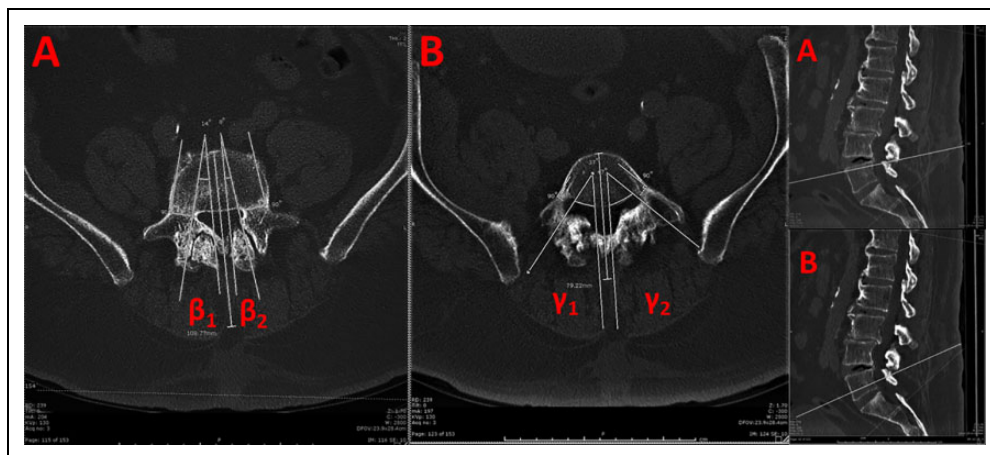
Axial and sagittal computed tomography (CT) scan images demonstrating measurement of the change in transverse pedicle angle (Δ TPA) based on the axial slice position in the cranial-caudal direction. Measurements at the (A) cephalad and (B) caudal axial sections of L5 pedicle. Cephalad TPA was calculated as $(\beta_1 + \beta_2)/2$. Caudal TPA was calculated as $(\gamma_1 + \gamma_2)/2$. Δ TPA was calculated as the difference between cephalad and caudal TPA values.
